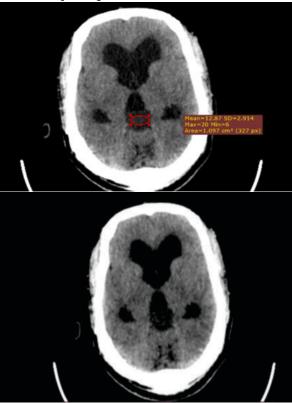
Plain CT Brain shows fluid density lesion (CT: 12 HU) in pineal region.
